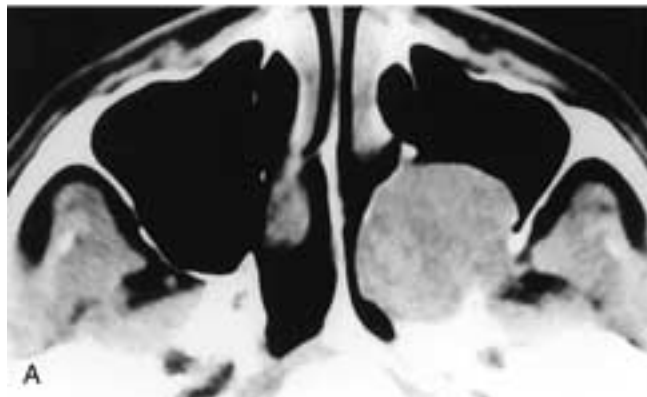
Axial CT scan (A) and sagittal T1-weighted, fat-suppressed, contrast-enhanced MR image (B) show an expansile mass in the pterygopalatine fossa that has remodeled the posterior maxillary sinus wall anteriorly. This patient had a schwannoma.
